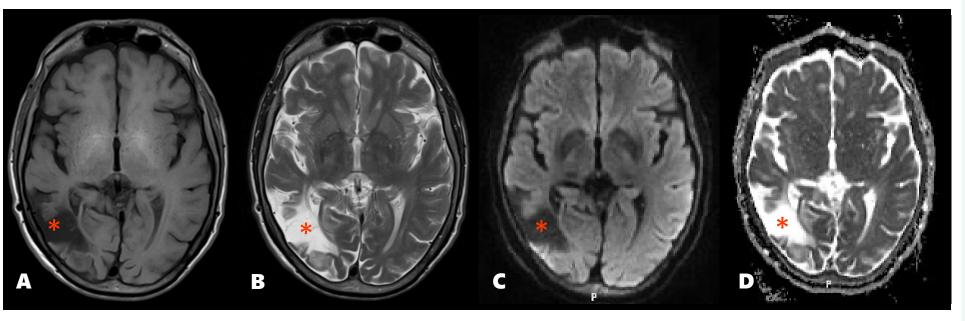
Chronic right middle cerebral artery territory infarct (asterisks) as seen on MRI. Hypointense on T1-weighted and hyperintense on T2-weighted images. Low signal on DWI and high signal on the ADC map.
